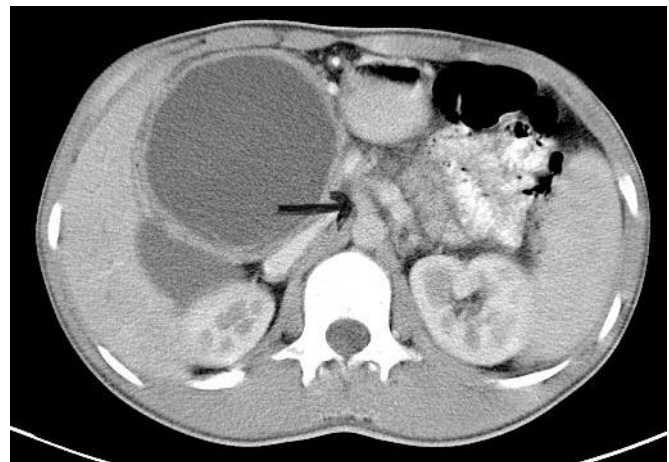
CT of abdomen showing Superior Mesenteric Artery (SMA) arising from the aorta. (indicated by arrow) Superior Mesenteric Vein is to the right of the SMA. SMA and SMV are adjacent to the cyst.
